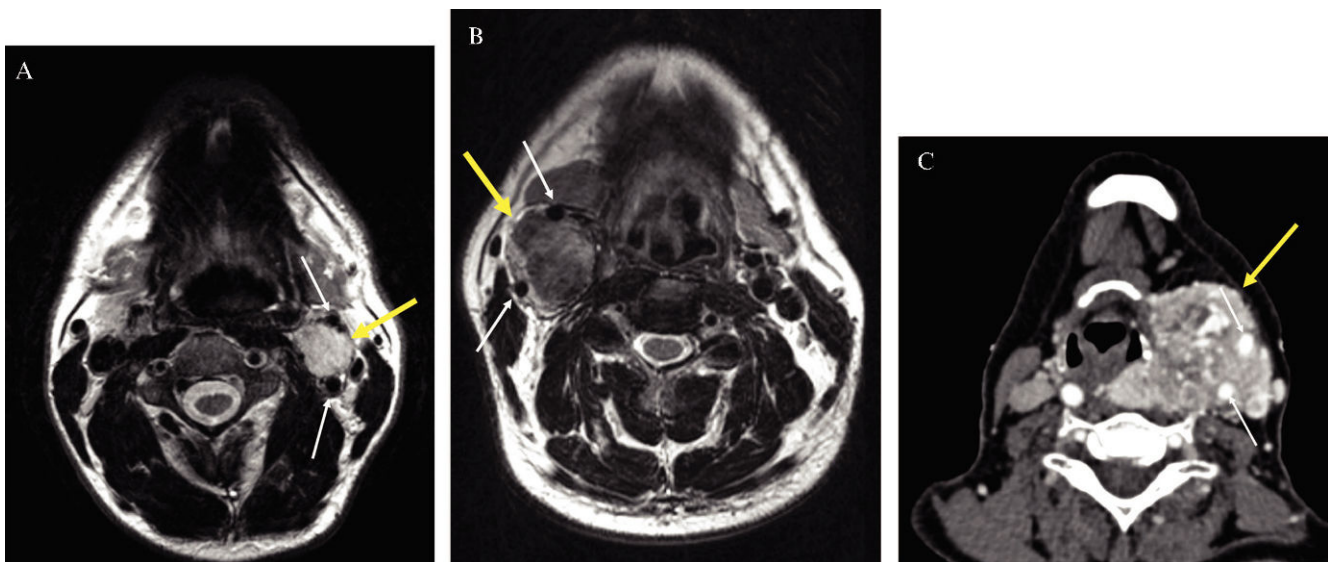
Shamblin classification. The Shamblin classification is based on involvement of the carotid arteries, which are shown by white arrows in A–C. The tumors are indicated by yellow arrows. (A) CBT (class I): the axial T2-weighted MRI shows a CBT in a typical location. Bulging of the left carotid bifurcation without any encasement of the carotid vessels. (B) CBT (class II): axial T2-weighted MRI showing a right-sided CBT with a partial encasement of the internal and external carotid artery. (C) CBT (class III): an axial slice of CT-angiography reveals a huge left-sided CBT with a complete encasement of the carotid vessels. In this case, bone destruction of the skull base, attributed to the enormous CBT, was also detected by CT (not shown).
